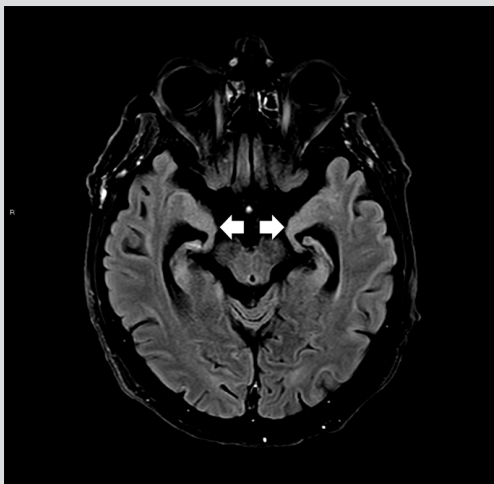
T2 FLAIR weighted image showing symmetrical atrophy (white arrowheads) of the mesial temporal lobes
